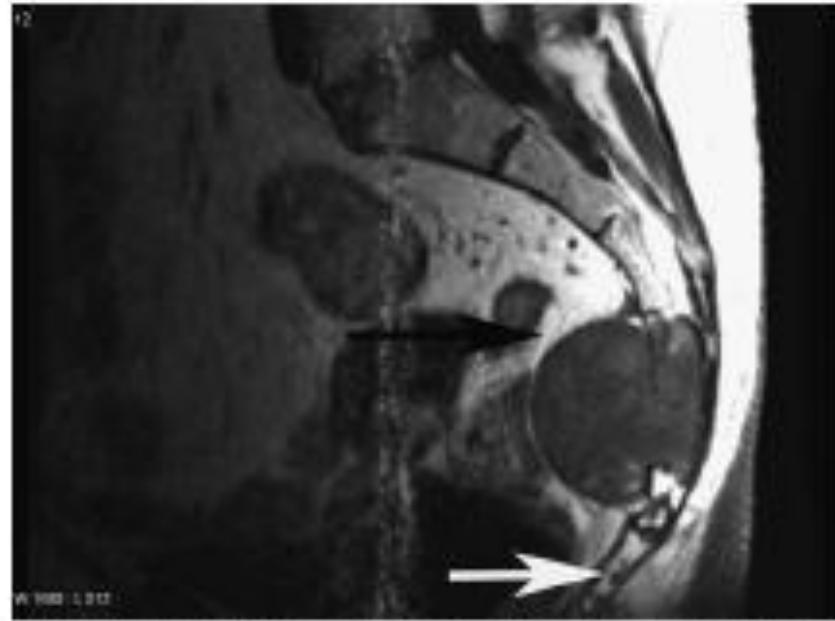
T1-weighted MR image showing a well-delineated tumor mass with low signal intensity in front of the sacrum and within the spinal canal (black arrow). Also seen are 2 intraosseous cocygeal lesions with irregular nodule contours and similar signal intensities (white arrow).
